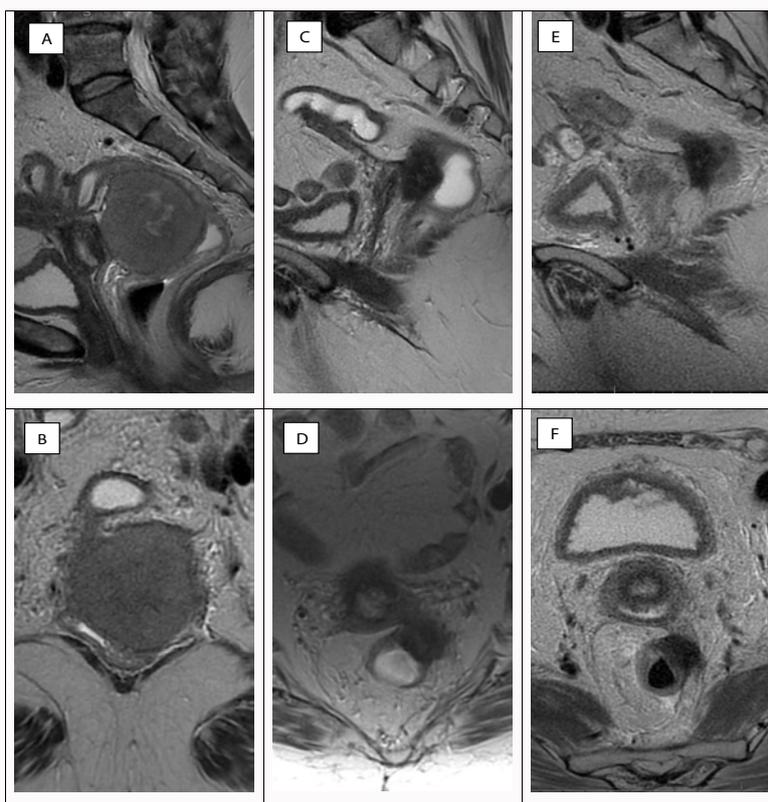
Pelvic MRI T2: Upper panel shows sagittal images. Lower panel corresponding axial images. A/B: Baseline; C/D: Immediately post-treatment completion; E/F: 5 months after treatment.
